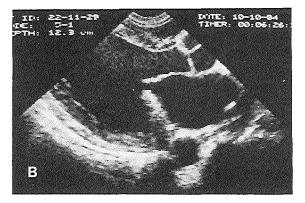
Left ventricular long axis views obtained from a patient with severe mitral valve incompetence. Intraoperative echocardiograms show a partial dehiscence of the posterior mitral valve leaflet from its normal chordal attachments (panel A, arrows). Reconstructive surgery was performed by excising the pathologic part of the posterior mitral valve leaflet. Postoperative epicardial echocardiographic investigation before the chest was closed shows the reconstructed posterior mitral valve leaflet (B). Left ventricular contrast study (panel C) revealed a competent mitral valve. Ao=aorta; LV=left ventricle.
